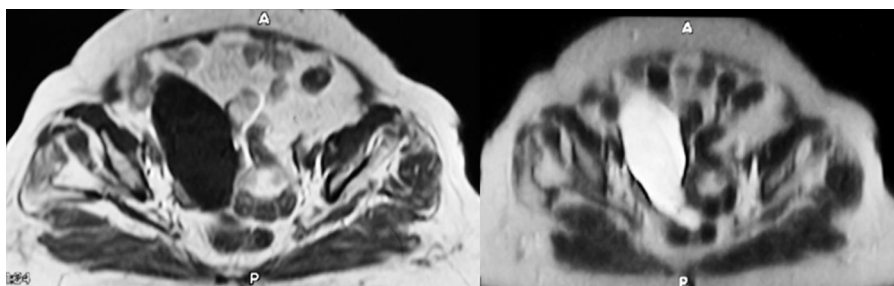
Appearance of the cystic mass on abdominal MRI.
